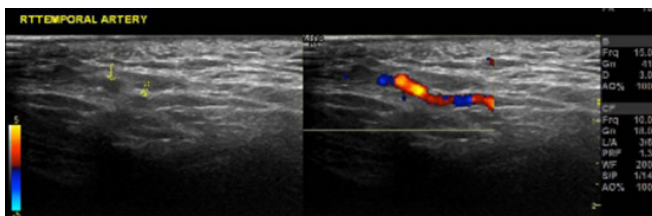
Color Doppler (right panel). Color flow is present within the lumen, confirming the structure is an artery. The lumen appears narrowed but patent, which is typical in GCA. Flow may look irregular due to luminal compression by the inflamed wall. Halo sign is the circumferential, homogeneous hypoechoic (dark) thickening of the arterial wall. This image shows a right temporal artery ultrasound with a positive halo sign, consistent with active giant cell arteritis (temporal arteritis).
